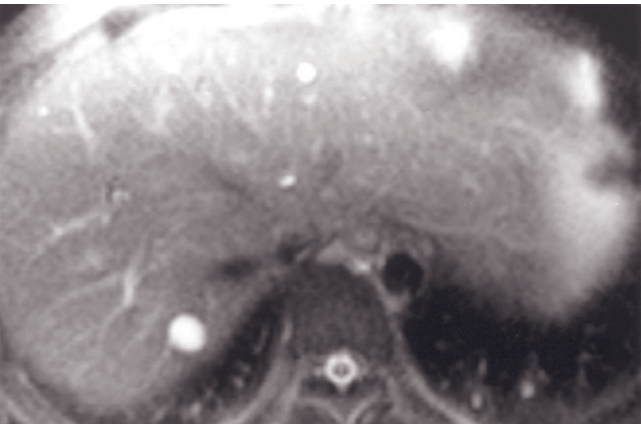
Simple unilocular cysts. T2-weighted SS-ETSE (*a, b*), SGE (*c, d*), and immediate (*e, f*) and 90-s fat-suppressed (*g, h*) postgadolinium SGE images in the same patient but at different levels. There are two well-defined lesions (arrow, *a, b*) that are homogeneously high signal on T2-weighted images (*a, b*) and homogeneously low signal on T1-weighted images (*c, d*) and show no enhancement after administration of gadolinium (*e-h*), consistent with simple liver cysts.
